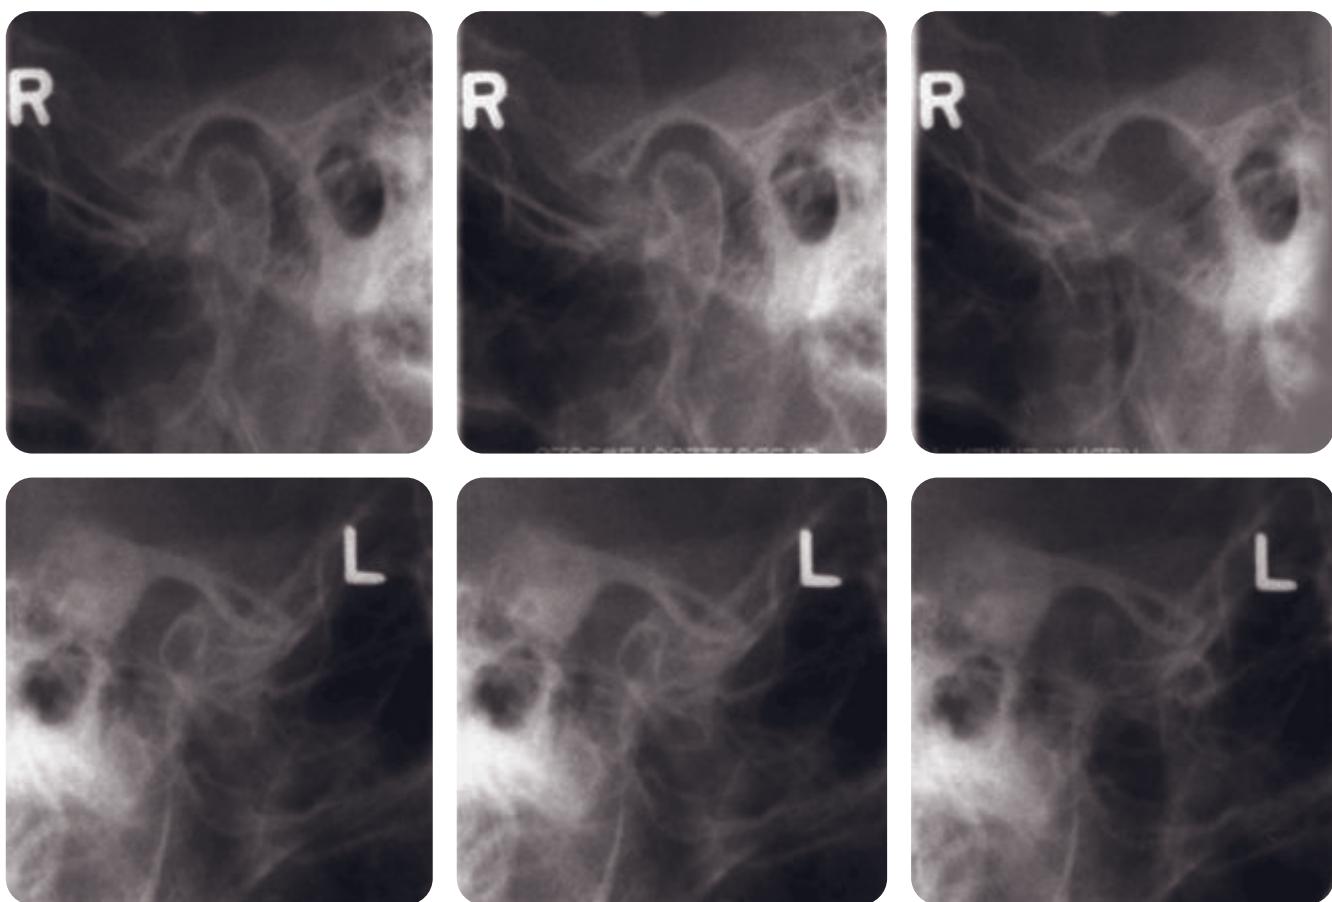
Pretreatment transcranial radiographs. Note that the left condyle is significantly smaller than the right condyle. This anatomic observation correlates to the lower incisal plane sloping up to the left, the side of the smaller condyle.
